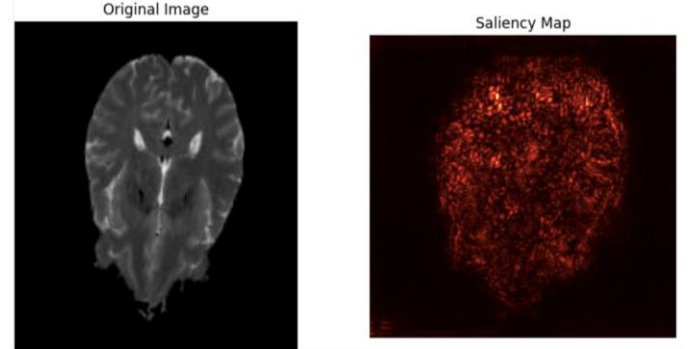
Original MRI scan of Parkinson's Disease and the Saliency Map from the Pre-trained Model VGG16
